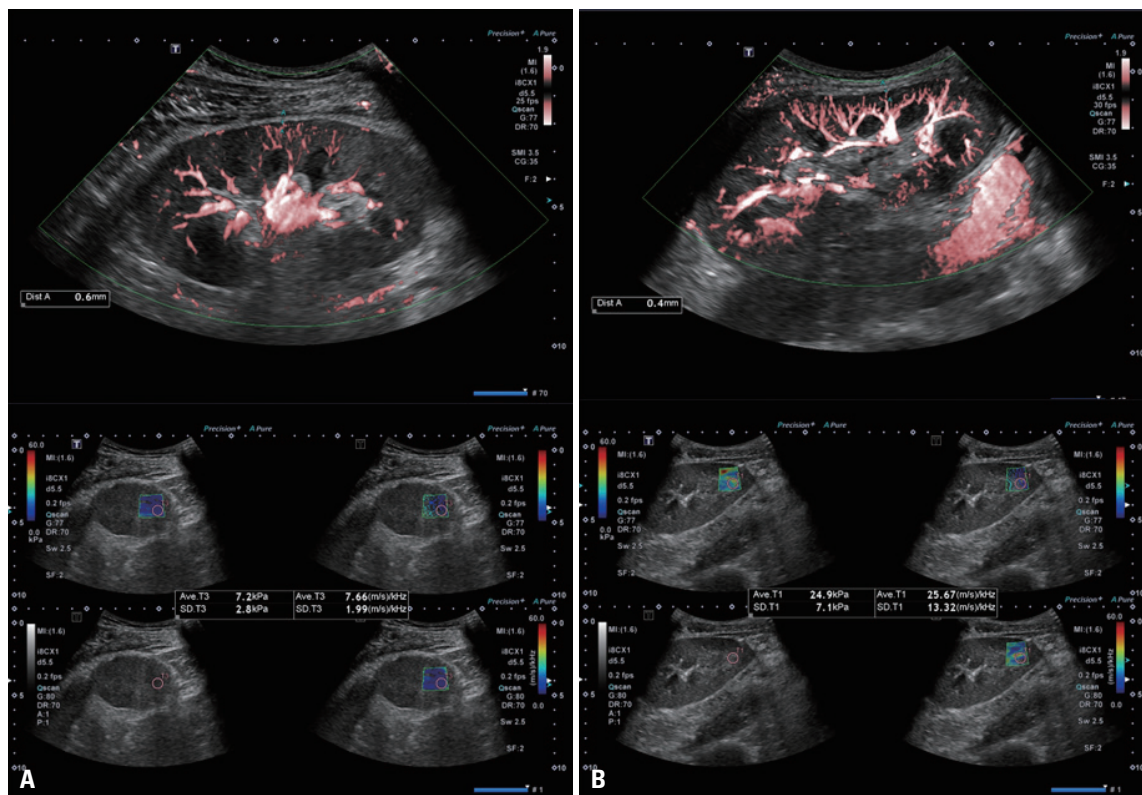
Examples of ultrasound images for (A) TCMR and (B) non-TCMR. In SMI, SMI-VI and the distance from vessels to capsules were measured. In shear-wave imaging, elasticity, and dispersions were measured more than 5 times, and the average value was calculated. TCMR, T cell-mediated rejection; SMI-VI, superb microvascular imaging-vascular index.
